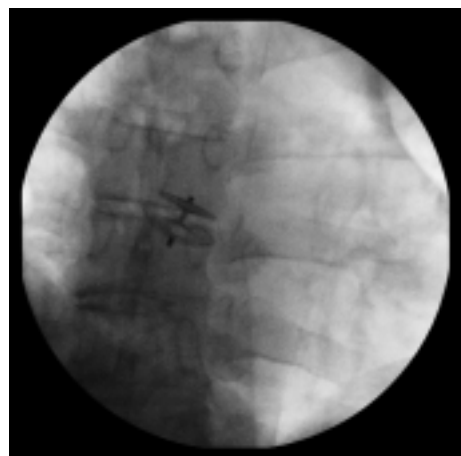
Radiographic appearance of the Amplatz device after deployment.
